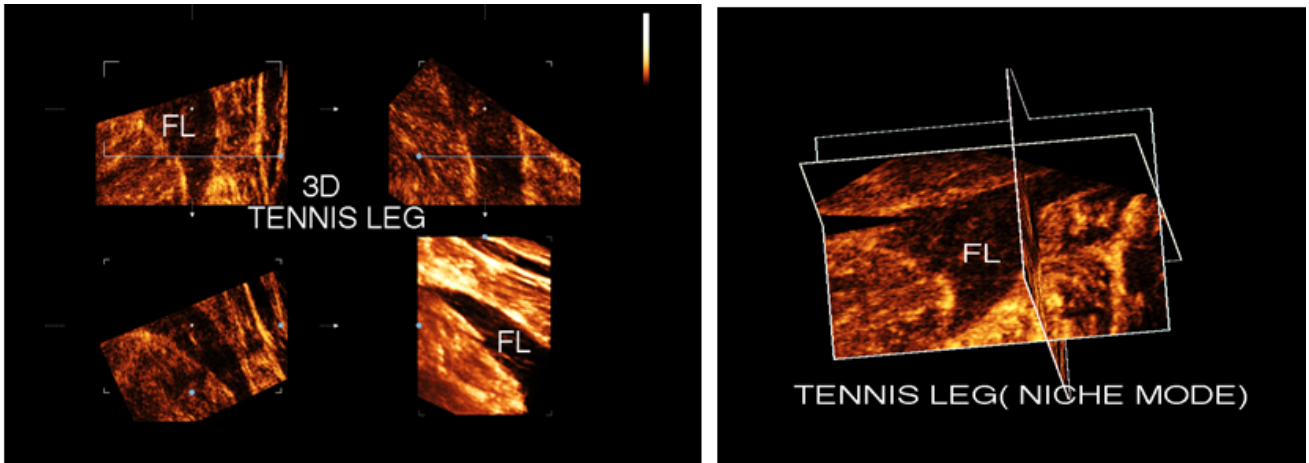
3D reconstruction of grade 11 muscle strain (tennis leg), b. 3D sonography reconstruction with niche mode of grade 11 muscle strain (tennis leg)
